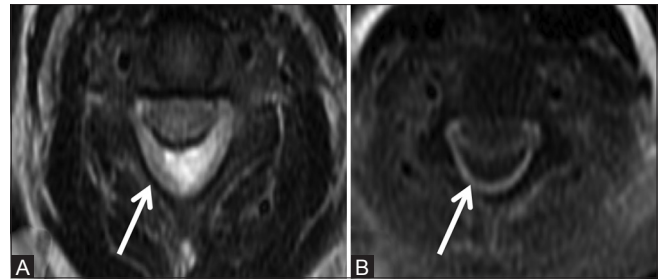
(A and B): Infective: Pyogenic abscess: Axial T2-weighted image (A) shows hyperintense collection (arrow) in the posterior epidural space, which shows peripheral enhancement on post-contrast axial image (B)
